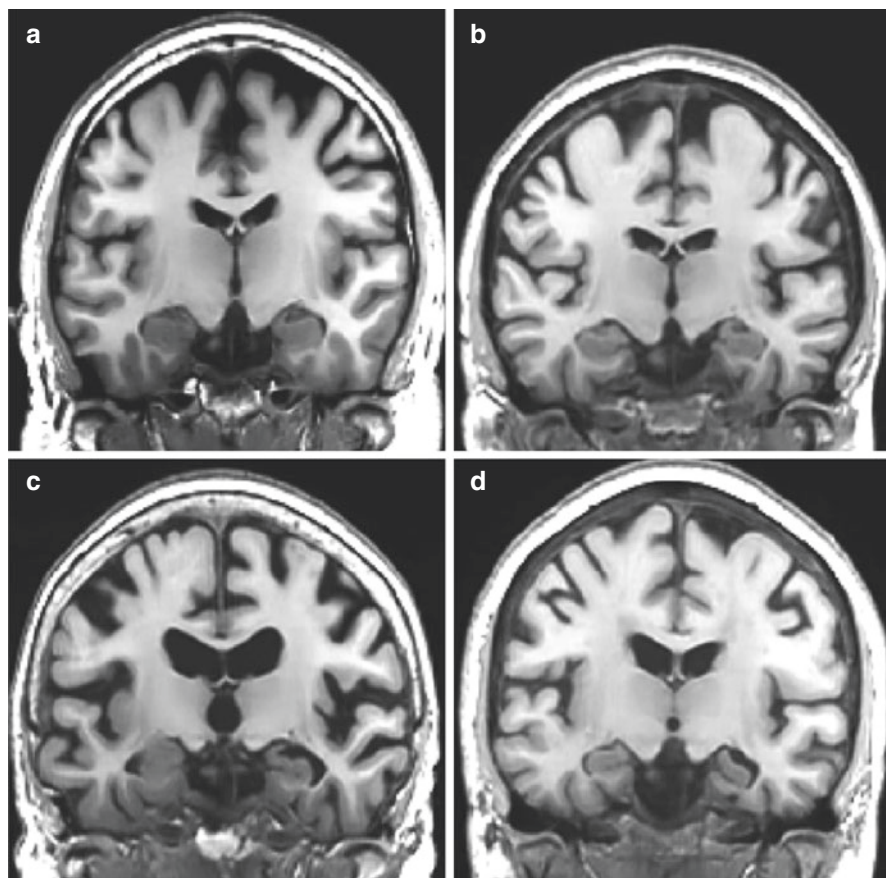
Sample of MRI coronal sections showing regional atrophy. Subjective visual rating and linear measurements of the medial temporal lobe atrophy can be assessed on these MR films: (a) absent, (b) minimal, (c) moderate, and (d) severe
